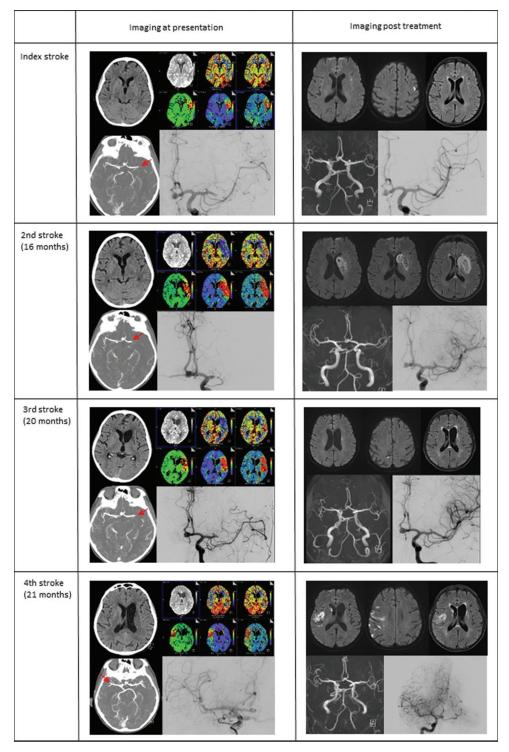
Imaging findings at admission and postmechanical thrombectomy in woman with 4 recurrent ischemic strokes due to primary antiphospholipid syndrome. Left box: Upper left: Native computed tomography (CT); lower left: CT angiography (red arrows indicate the large vessel occlusion); upper right: CT perfusion; lower right: Conventional digital subtraction angiography (DSA), Right box: Upper row: Diffusion-weighted magnetic resonance imaging; lower left: Time-of-flight-magnetic resonance-angiography; lower right: Conventional DSA
